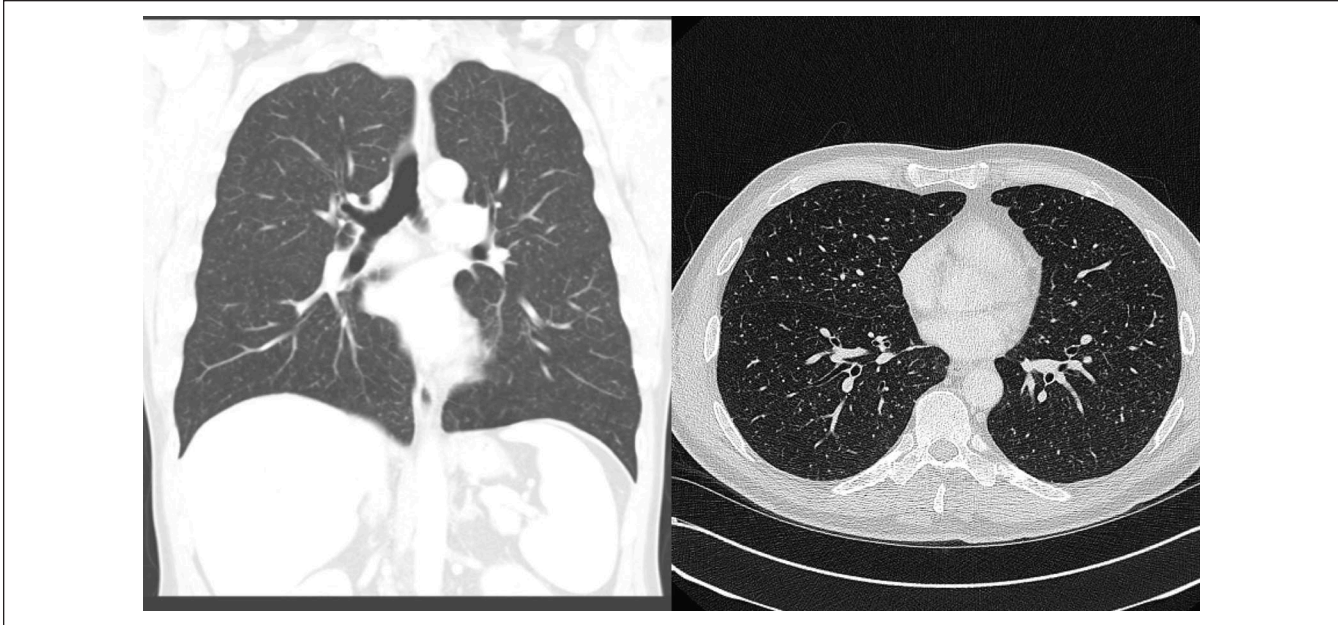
CT chest findings of miliary nodular pattern diffusely in all lung fields.
